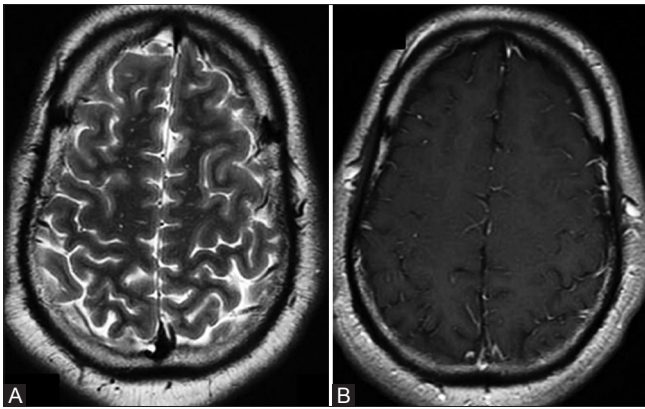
(A and B): Follow up MRI brain performed 12 months after treatment in case 1 shows complete resolution of edema (A) and enhancing lesion (B)
